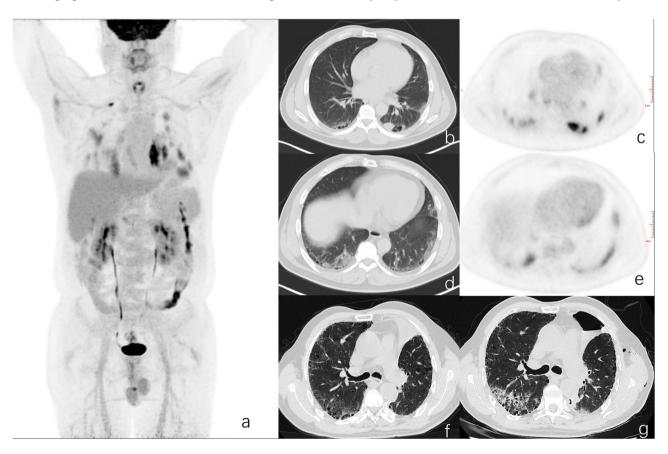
A typical case with high FDG uptake in the idiopathic interstitial pneumonia area on 18 F-FDG PET/CT. The patient was a 55-year-old man who underwent left lower lobectomy with lymph node dissection via video-assisted thoracoscopic surgery for adenocarcinoma and respiratory distress on postoperative day 40 due to postoperative acute exacerbation. (a) A MIP PET image. (b, d) preoperative chest CT.(c, e) preoperative 18 F-FDG PET/CT. (f, g) preoperative and postoperative day 40 image. Preoperative chest CT showed peripheral reticular opacities and ground glass located in the lung bases(white arrow). Hight FDG uptakes were observed in the areas, and the maximum standardized uptake value (SUVmax) was 5.8. The lung tumor was located in the left lower lobe and 18 F-FDG uptake matched to the location was observed(black arrow). Newly formed reticular opacities were observed not only in the left lung base but also in the left upper lobe as well as in the right residual lobes(arrow head)
